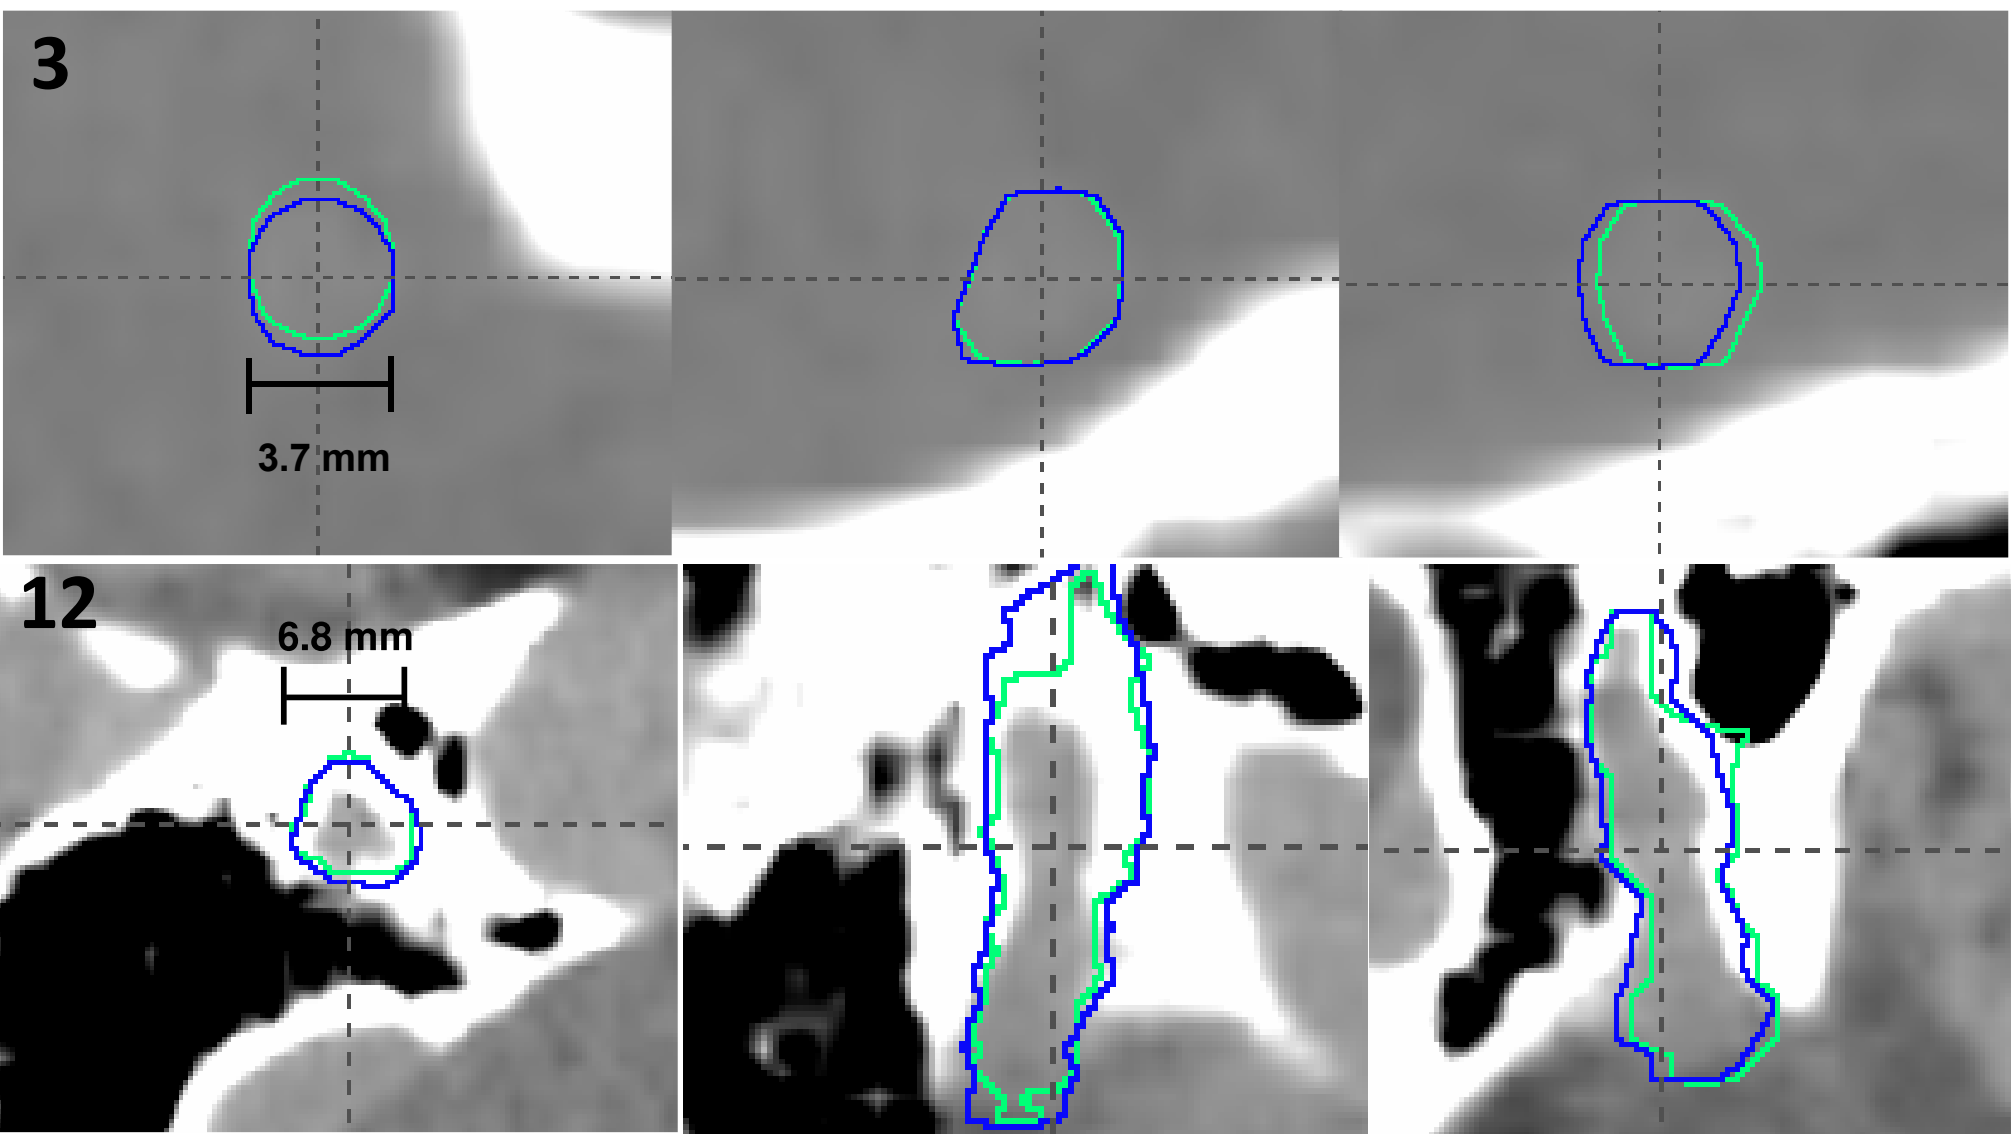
Axial, coronal, and sagittal CT images showing example distorted (blue) and undistorted (green) PTV contours for two patients.
